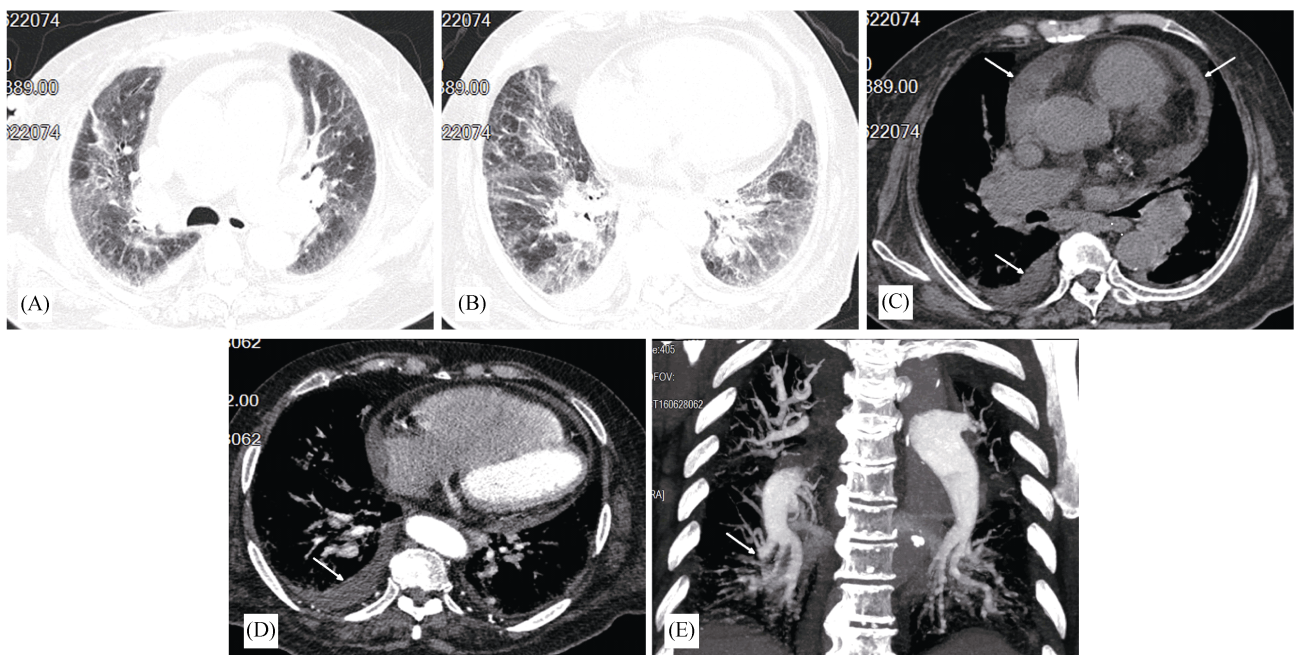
Chest CT and CT angiography in a 82-year-old woman with right lower pulmonary artery embolism. (A&B): Axial CT images shows ground-glass density in bilateral lung field, representing interstitial pulmonary edema; (C&D): axial CT plain scan and contrast enhanced images shows the presence of pericardial and bilateral pleural effusion (arrow); lower right pulmonary artery widened; (E): coronal maximum intensity projection image from pulmonary artery CT angiography scan shows contrast filling defects and an abrupt cutoff at segmental branches of right lower pulmonary artery (arrow).
